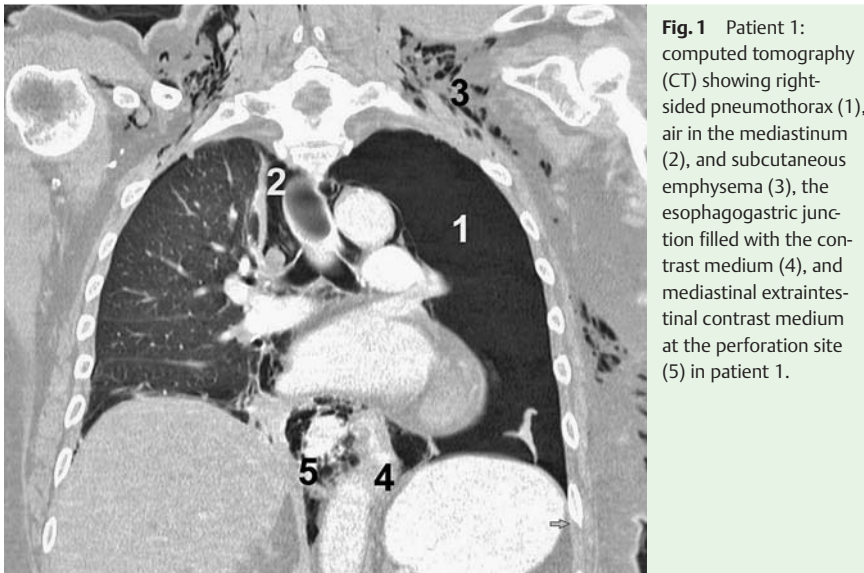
Patient 1: computed tomography (CT) showing right-sided pneumothorax (1), air in the mediastinum (2), and subcutaneous emphysema (3), the esophagogastric junction filled with the contrast medium (4), and mediastinal extraintestinal contrast medium at the perforation site (5) in patient 1.
